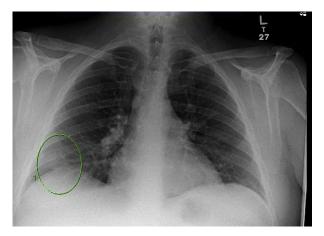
Chest radiograph showing a mass-like opacity at the right lung base over the right hemidiaphragm.
